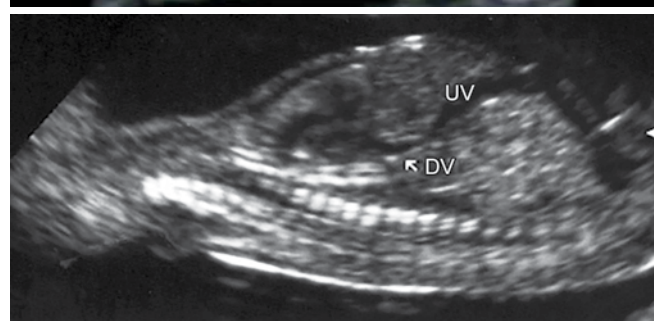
B-mode image of venous return in a fetus of 12 weeks of gestation. UV: Umbilical vein; DV: Ductus venosus; IVC: Inferior vena cava and color Doppler with aliasing representing the turbulence due to the increased velocity in the inlet of the ductus venosus
